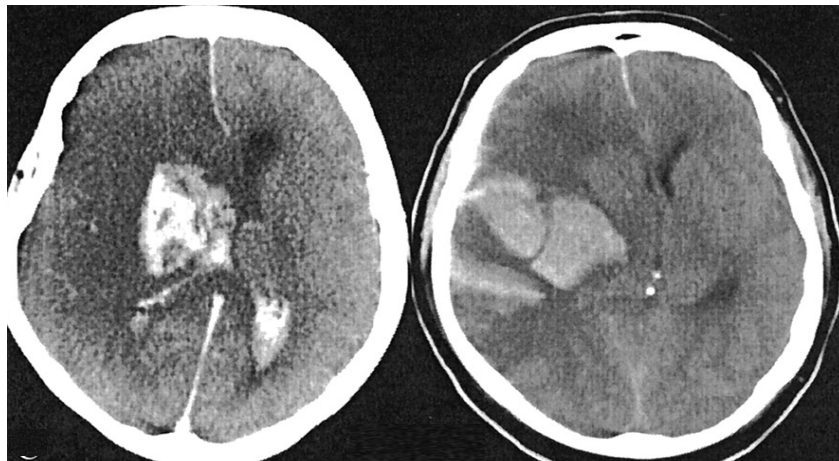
Non-contrast CT scan showing an example of PH-1 with a haemorrhage occupying <30% of the infarcted area and only mild space-occupying effect (left) and PH-2 with a haemorrhage occupying >30% of the lesion volume with significant mass effect (right).
